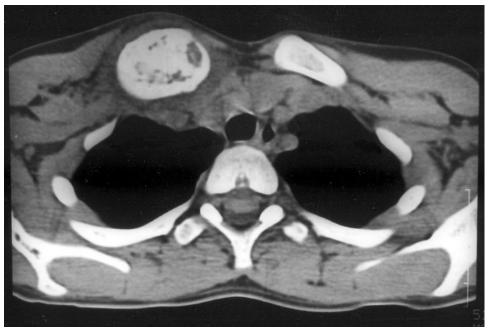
CT scan of the right SCJ region: extensive periosteal reaction of the medial portion of the clavicle with multiple areas of osteolysis and cortical destruction.
